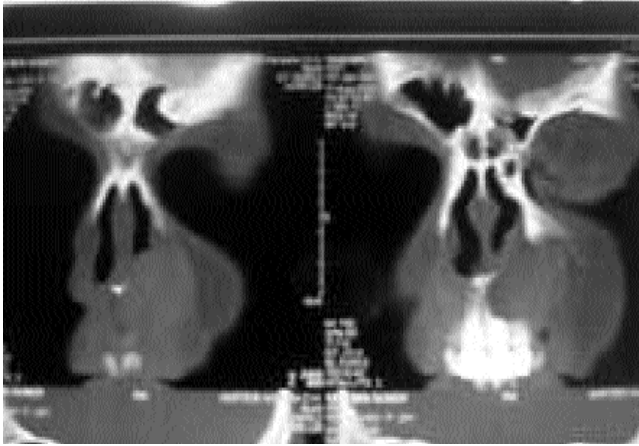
Maxillofacial CT.
